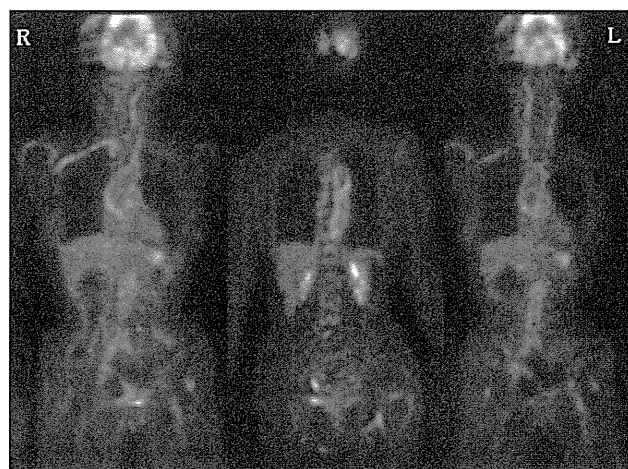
¹⁸F-Fluorodeoxyglucose positron emission tomography (FDG-PET) demonstrated increased glucose uptake in the ascending aorta, both carotid arteries, both subclavian arteries, and from the descending aorta to both common iliac arteries.
